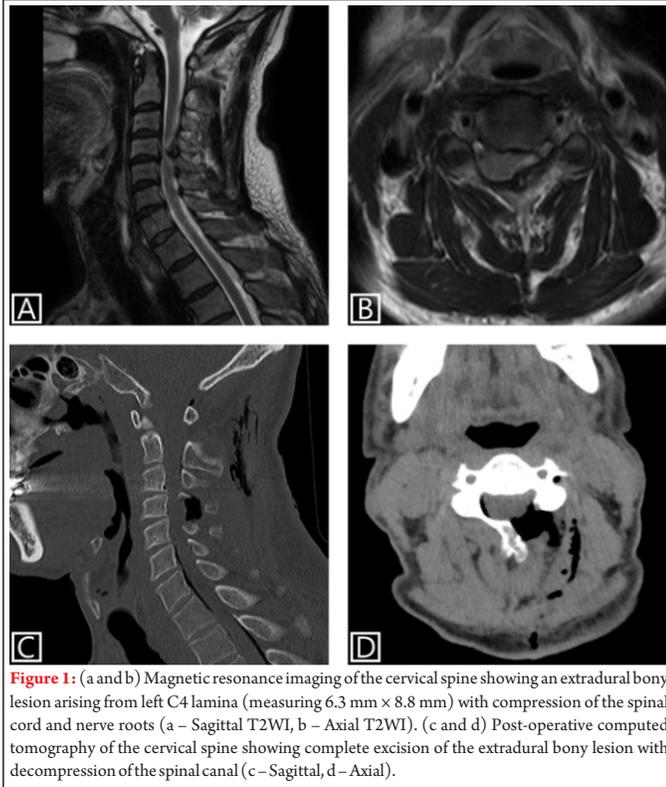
(a and b) Magnetic resonance imaging of the cervical spine showing an extradural bony lesion arising from left C4 lamina (measuring 6.3 mm × 8.8 mm) with compression of the spinal cord and nerve roots (a – Sagittal T2WI, b – Axial T2WI). (c and d) Post-operative computed tomography of the cervical spine showing complete excision of the extradural bony lesion with decompression of the spinal canal (c – Sagittal, d – Axial).
